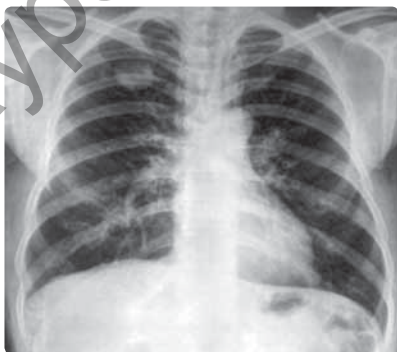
Chest X-ray PA view showing a solitary pulmonary nodule in right upper zone
